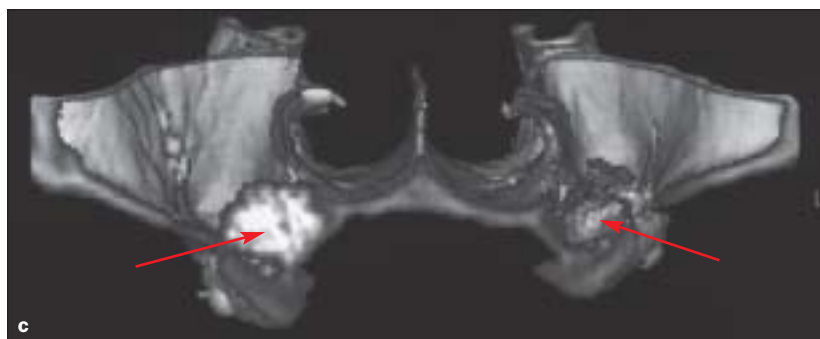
Preoperative 3-dimensional (3D) computerized tomogram (CT) demonstrating that a large part of the alveolar crest has atrophied.
